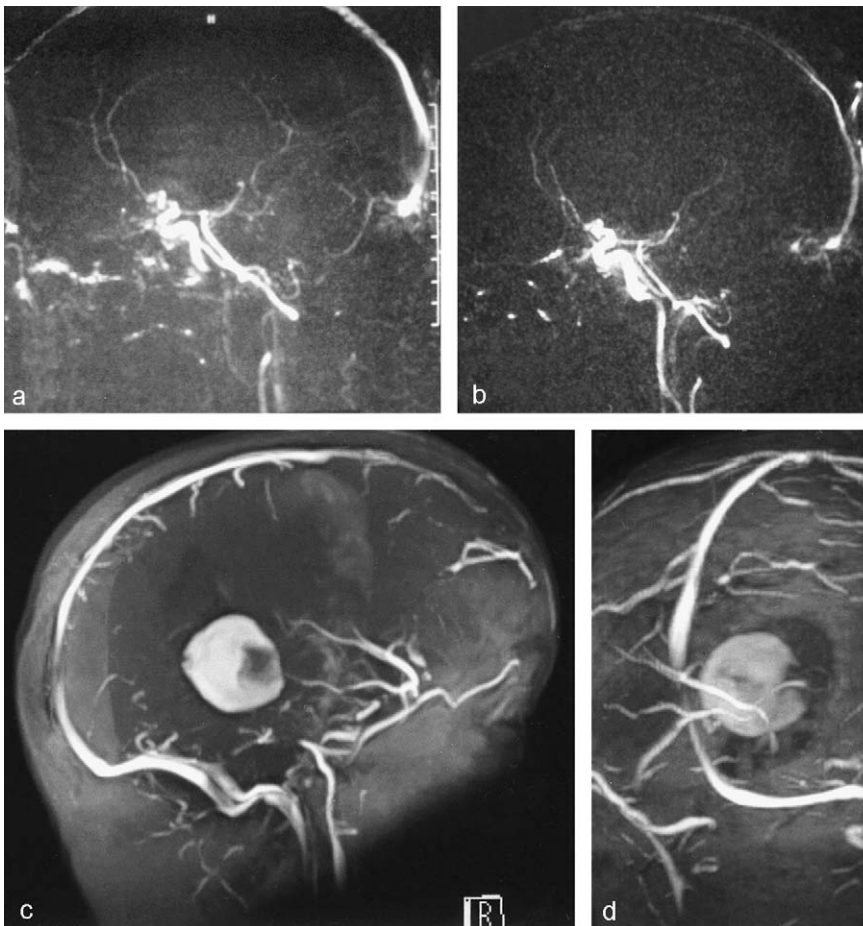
a and b: Phase-contrast MRI angiography, velocity encoding (VENC) 10–60; neither incoming blood flux towards the aneurysm nor flux inside the malformation are detectable. c and d: MRI venography, time-of-flight (TOFF) 2D; venous drainage from the aneurysm and straight sinus are barely visible. These findings confirm the thrombosis of the malformation.
